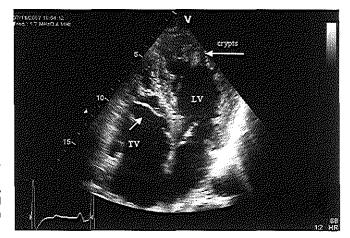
Echocardiogram (4-chambered view, apex up) of patient IV-4 with NCCM and Ebstein anomaly. Prominent trabeculations are visible, mainly in the left ventricular apex and an apical displacement of the septal and posterior leaflet from the atrioventricular ring.
